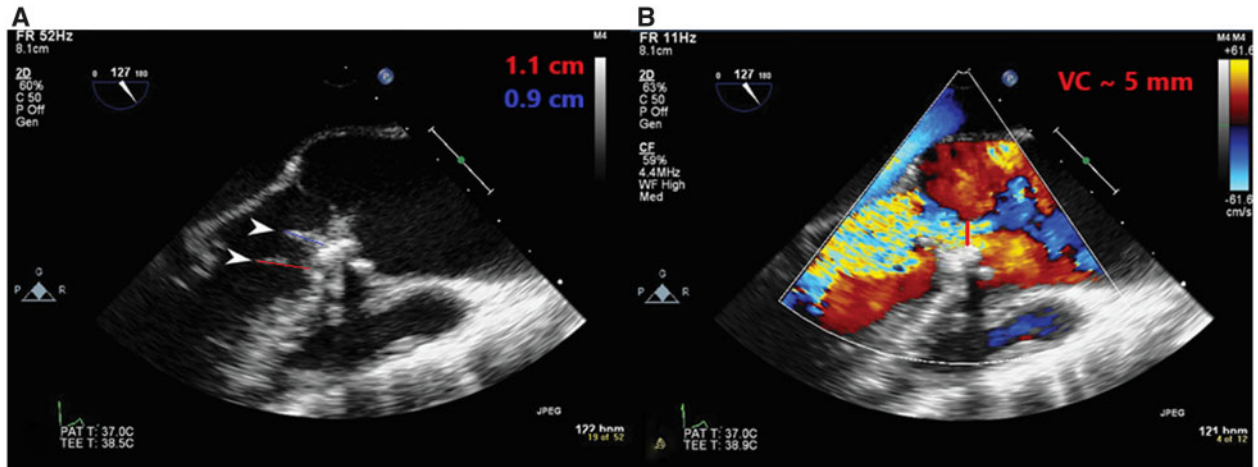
(A) Long-axis midoesophageal transoesophageal echocardiography view zoomed in the aortic valve showing vegetations (white arrowheads) on the aortic valve and (B) resultant severe aortic regurgitation (vena contracta ~ 5 mm).
